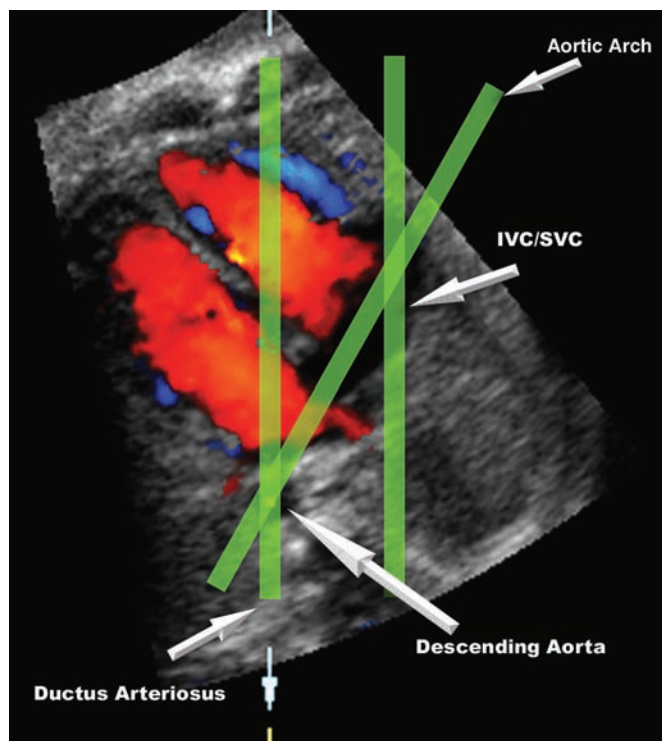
This image shows the four-chamber view image with color Doppler extracted from a STIC 3D color Doppler volume. The green lines represent the scan planes where the additional views of the heart, such as IVC/superior vena cava (SVC) or aortic arch, can be obtained. The vertical axis of the display can be aligned with these scan planes by rotating the image plane and simultaneously maintaining the descending aorta as the pivot point by placing the cross-planar point in it. Typically, the ductus arteriosus plane is the plane that goes through the descending aorta (placed at 6 o'clock) upward, intersecting the left atrium, right ventricle and sternum. The IVC/SVC plane is a plane parallel to the plane of the ductus arteriosus and to the right of it close to the level of the right atrium. The aortic arch is a plane that can be found by rotating the four-chamber view plane around 35–40° from the ductus arteriosus plane and maintaining the descending aorta as the pivot point by keeping the cross-planar point there.
